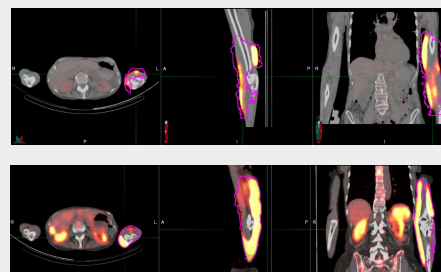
Segmentation and quantification of the extravasation using xSPECT/CT. The upper panel shows the subcutaneous distribution of the extravasated activity in the arm at the first time point, while the lower panel shows the whole-body redistribution of activity at the second time point.
